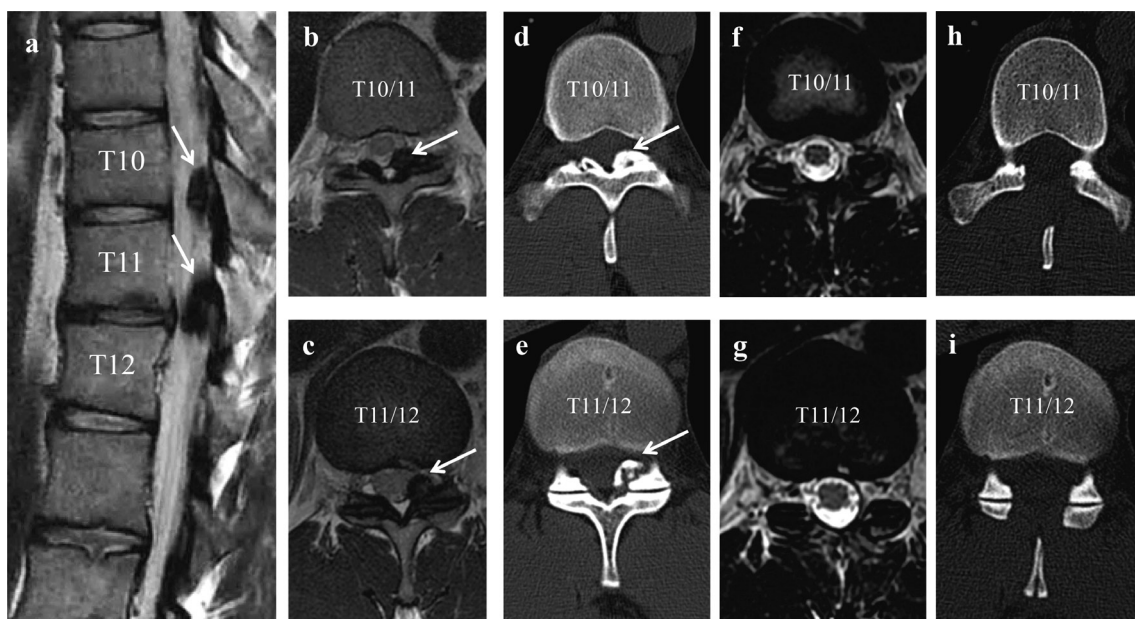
Pre- and postoperative computed tomography (CT) and magnetic resonance imaging (MRI) findings of Case 1. Sagittal MRI (a) and axial CT and MRI show ossification of the ligamentum flavum (arrows) at T10/11 (b, d) and T11/12 (c, e). Satisfactory decompression is achieved after the spinous process-splitting approach with no evidence of muscle damage (f, g, h, i).
